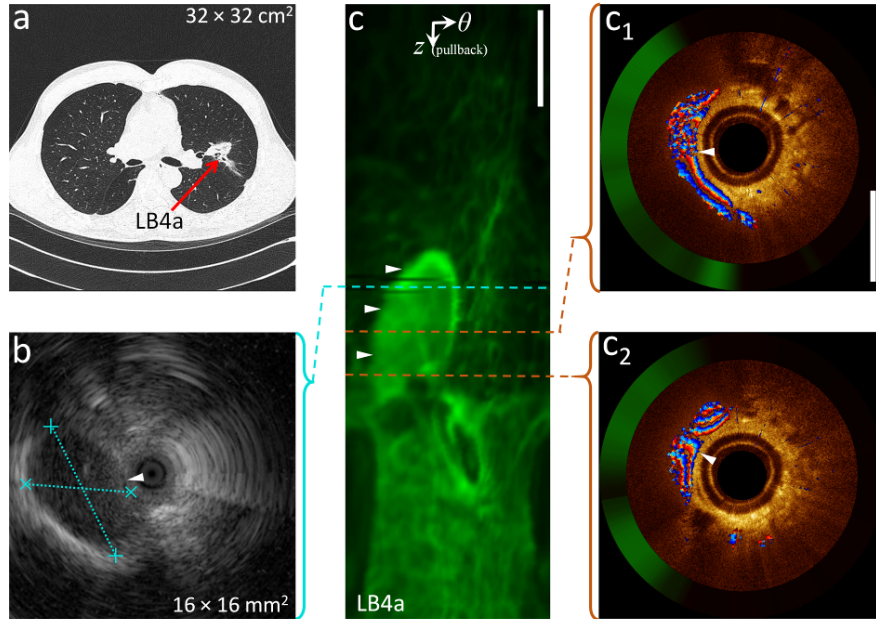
Differentiation of large blood vessels from nodules by DOCT-AFI: (a) a CT-scan showing a nodule in LB4a, (b) R-EBUS image of the nodule, (c) AF z - θ map of a pullback from the same airway site, (c_{1,2}) cross-sectional DOCT-AFI in Cartesian coordinates corresponding to the red dashed lines along the pullback. R-EBUS and DOCT-AFI are referenced with respect to the end of the guide sheath. ► indicates vessel location. Scale-bars are 1mm.
